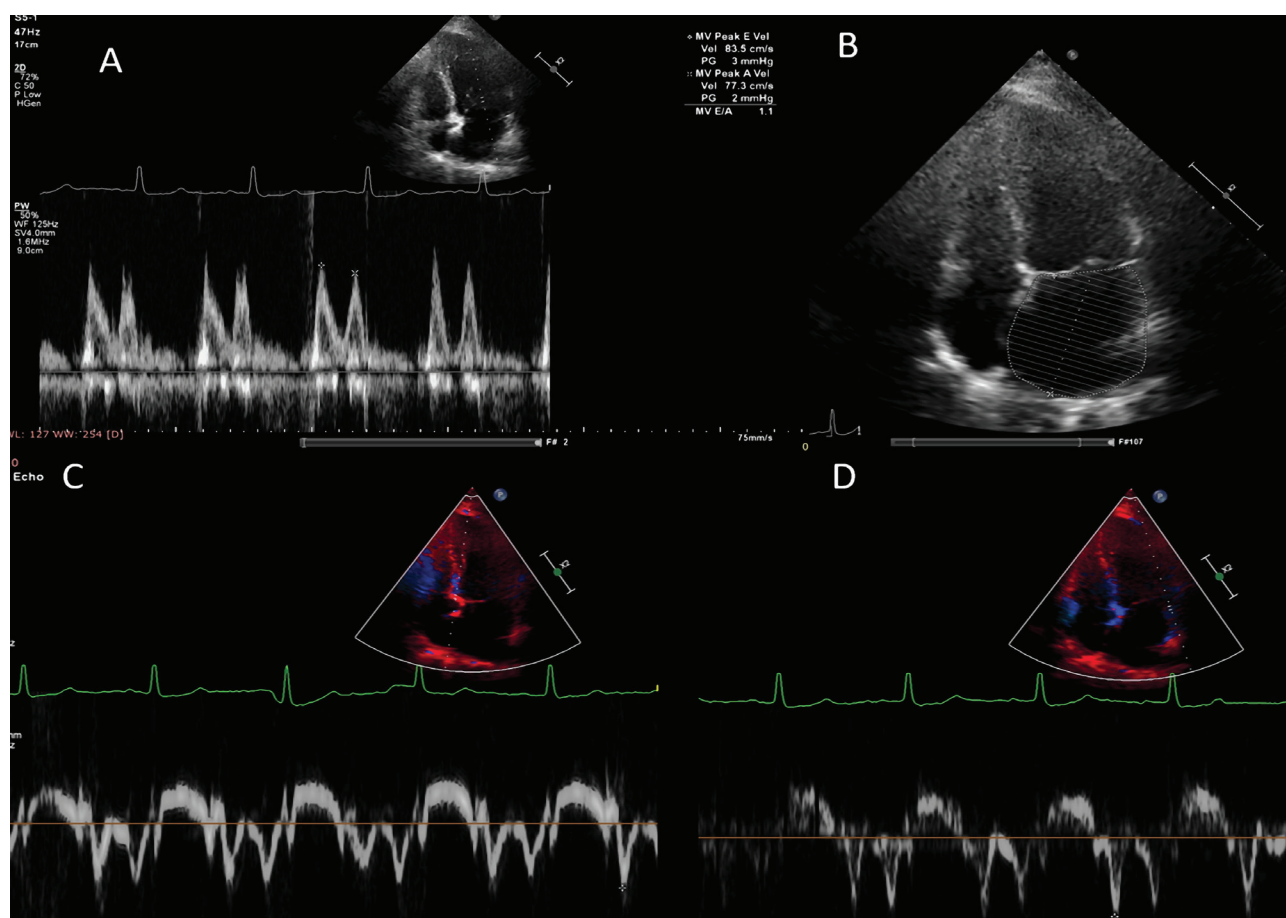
Transthoracic echocardiography. A – Apical 4-chamber view, pulse wave (PW) Doppler: E/A=1.1; B – Apical 4-chamber view: Enlarged left atrium; C, D – Tissue Doppler Imaging: septal e' velocity=9 cm/s, E/e'=8.5.
